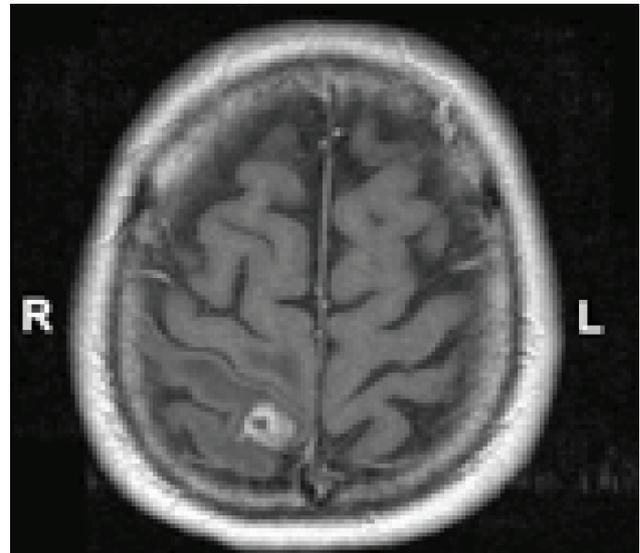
MRI slice view, tumor (lung CA metastasis)
